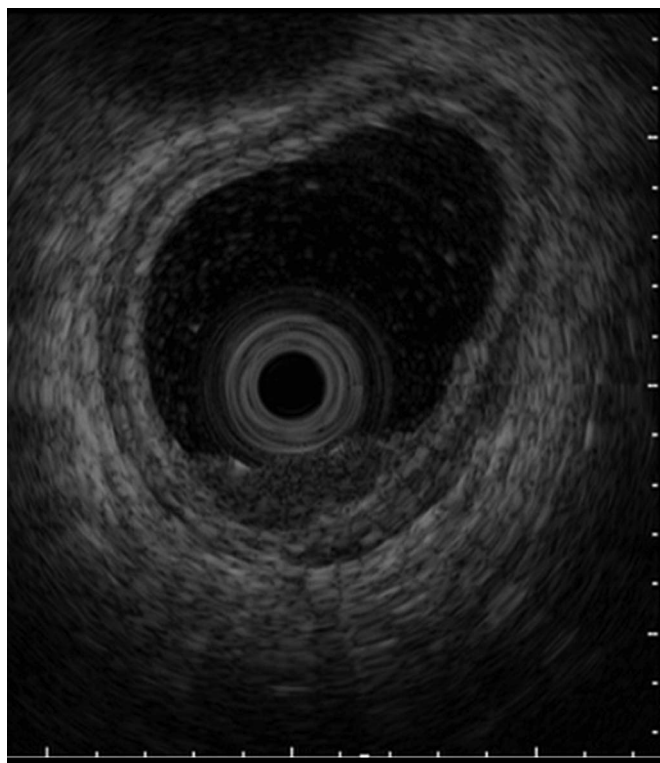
20-MHz miniprobe endoscopic ultrasound showing a hypoechoic 10 \times 4 mm lesion with an irregular shape in the submucosa, but an intact submucosal layer.
